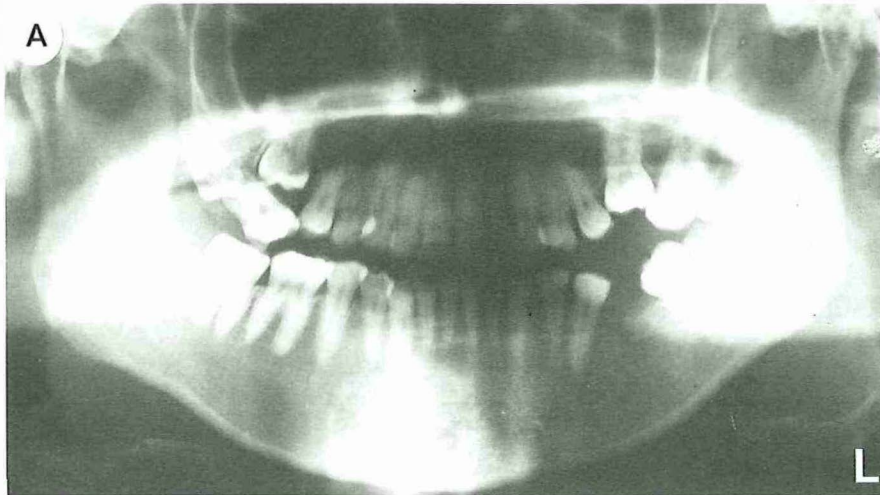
A Orthopantomogram of a 26-year-old female with secondary retention of the first molars in the maxilla. The right first molar was almost completely covered by surrounding tissues. The neighbouring teeth showed severe and moderate tilting. B Clinical view of the right side. C Clinical view of the left side.
